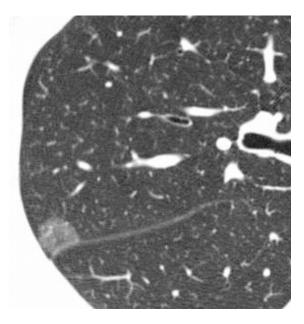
Thin-section CT shows a pure GGN in segment 2 of the right upper lobe.
